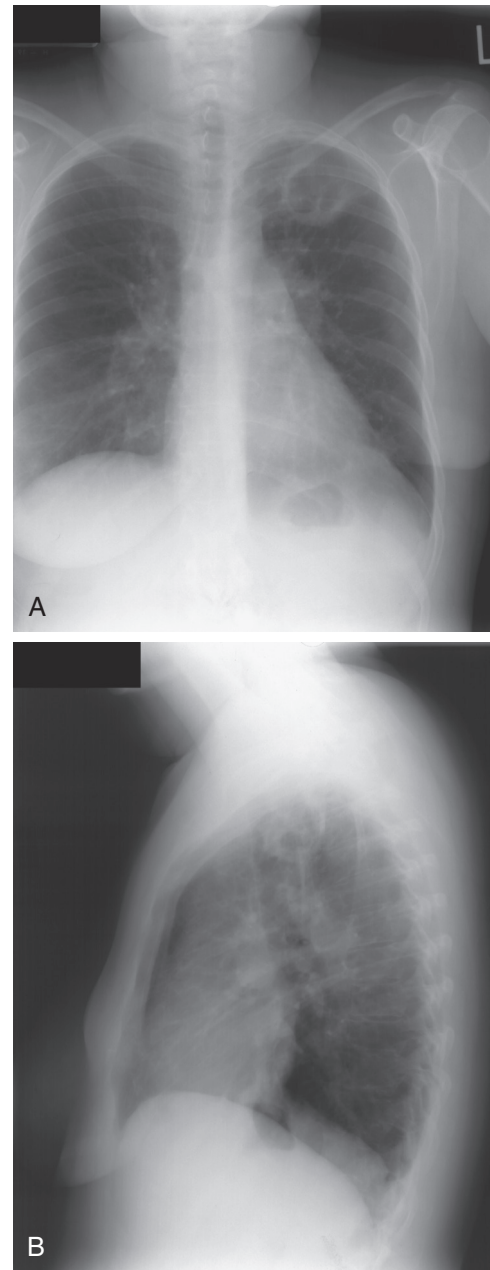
■ Posteroanterior (A) and lateral (B) chest radiographs demonstrating mucormycosis involving the left upper lobe.
